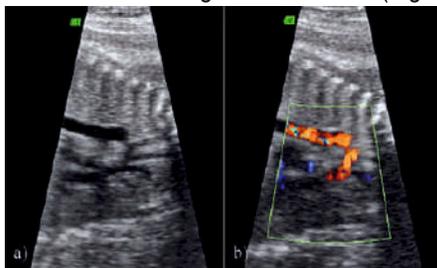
Fetal CoA in parasagittal view of aortic arch and the descending aorta: a) gray scale, b) color Doppler.
